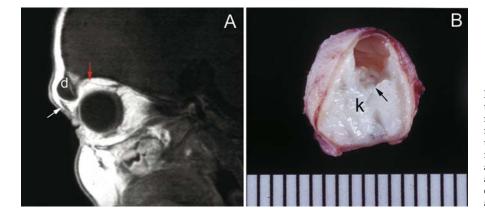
(A) A T1-weighted, sagittal MRI image showing a superior anterior dermoid (d). Note that the levator muscle is distorted with a kink posterior to the lesion (red arrow) and the septum is pushed inferiorly and anteriorly (white arrow). (B) The appearance of dermoid after surgical removal; contains a considerable amount of keratin (k) and a few hairs (black arrow).
